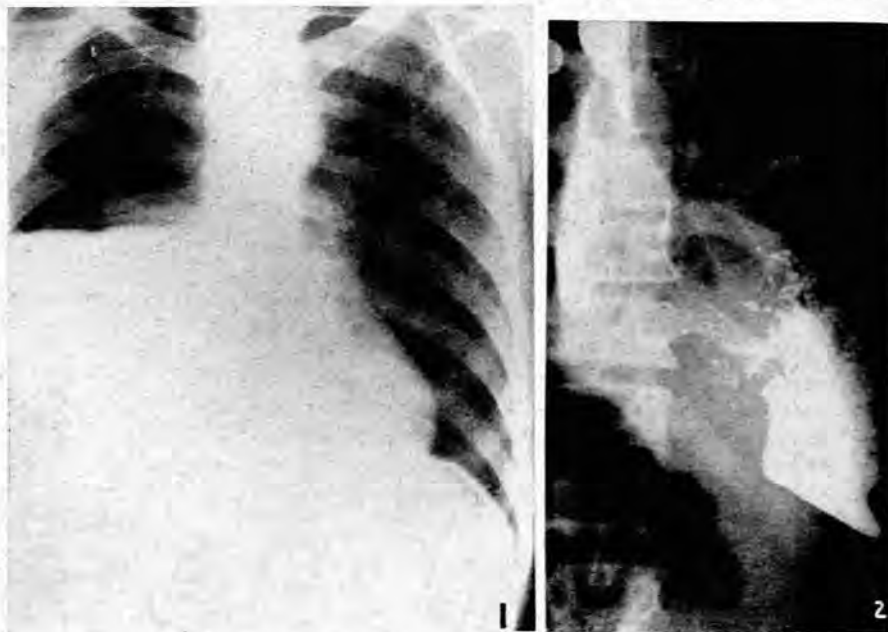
Case 1. Oesophago-pleural fistula. X-ray of chest.
